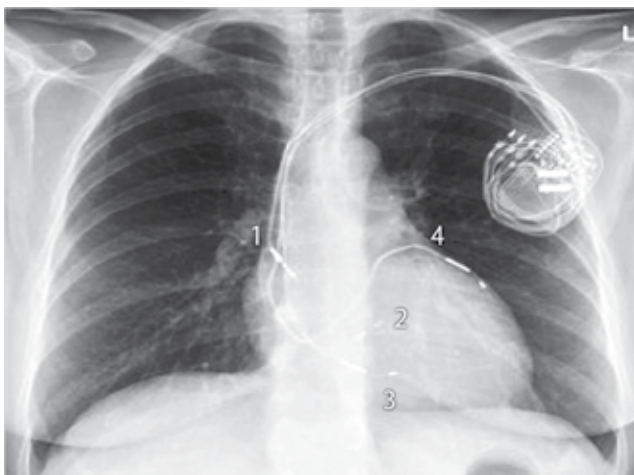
X-ray of the chest showing a CRT device with a RA lead (1), RV lead screwed in the RVS (2) and two LV leads. The first LV lead (3) is positioned in a posterior branch. Because no mechanical resynchronization could be obtained a second lead (4) was placed afterwards in an antero-lateral branch, after which mechanical synchrony was achieved.
